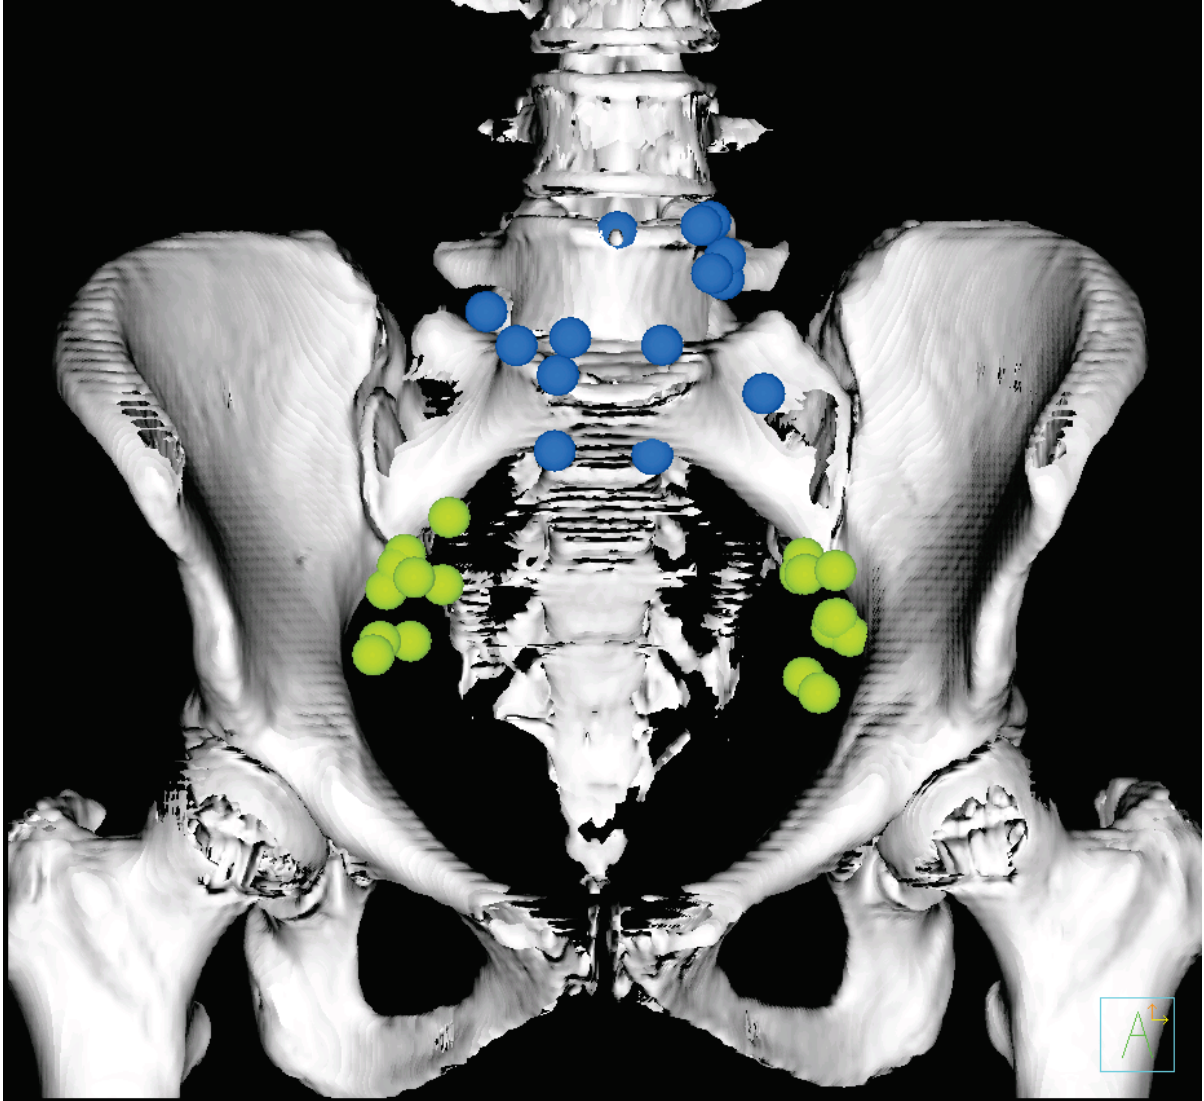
Approximate centroid locations of all analyzed nodes for all patients displayed on an atlas computed tomography image. The blue and green spheres represent nodes in the distal and proximal pelvic regions, respectively.
